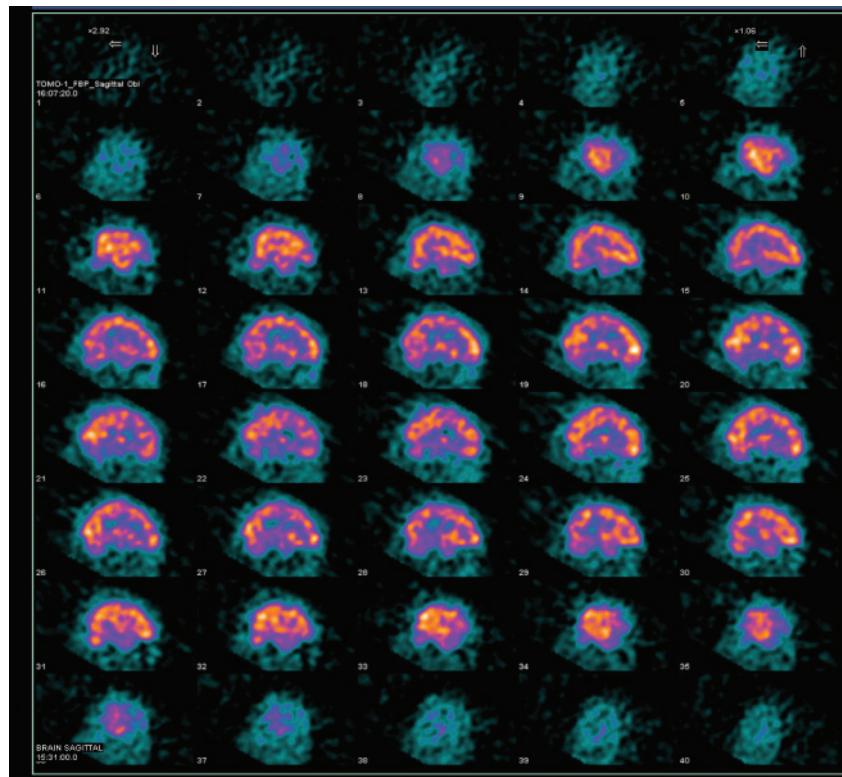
Sagittal view of brain SPECT
